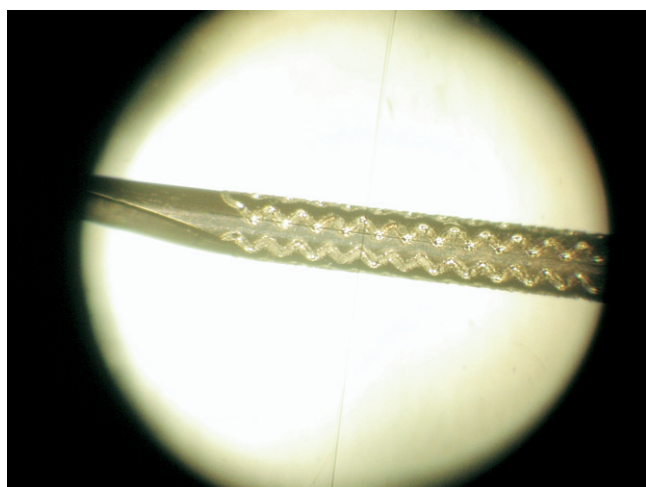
A laser-treated needle tip, to improve the visibility of the needle under ultrasound imaging. (Color version of figure is available online.)
